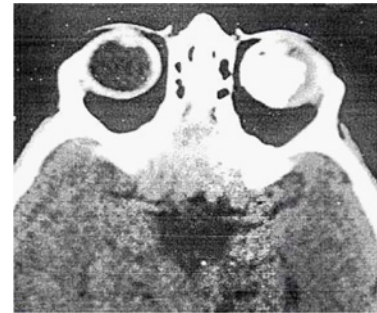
Axial computed tomography (CT) scan of unilateral retinoblastoma showing hyperintense calcified intraocular mass lesion (arrow) filling most of the globe.
